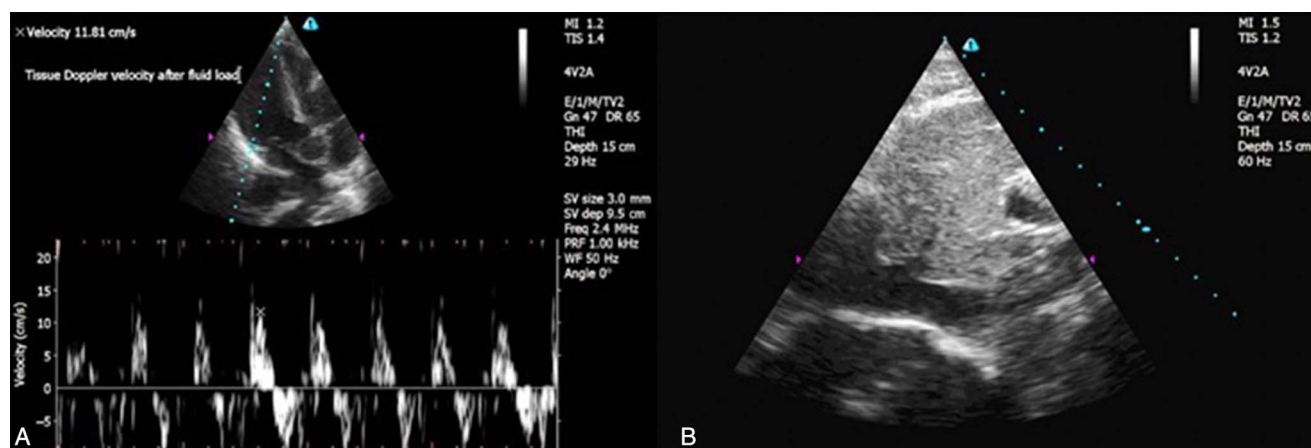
(A) Control bedside ultrasound (BUS) after fluid therapy revealed decreased TDI velocity of the right ventricle from the lateral annulus of the tricuspid valve. (B) Control BUS after fluid therapy revealed that the inferior vena cava is dilated and not collapsing sufficiently with respiration
